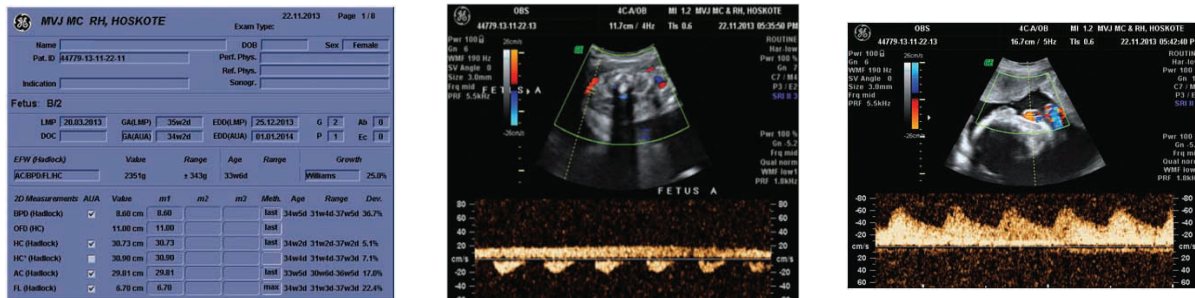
and empty urinary bladder. Umbilical artery doppler demonstrated absent diastolic flow suggestive of moderate placentofetal insufficiency [Table/Fig-5]. Twin B (Recipient twin) demonstrated breech presentation, corresponding to 34 weeks [Table/Fig-6], polyhydramnios (Deepest Vertical Pocket -12cm) [Table/Fig-7], over distended urinary bladder [Table/Fig-8]. Doppler demonstrated normal umbilical artery flow pattern [Table/Fig-9]. Because of the above mentioned findings, diagnosis of Monochorionic diamniotic twin live intrauterine gestations with features of Twin to Twin transfusion syndrome (stage-3) with stuck donor twin was given. With adequate blood transfusion patient was taken up for emergency LSCS. Twin A was delivered first by breech extraction with excess liquor, second twin was extracted with membrane tightly wrapped around the baby. Recipient twin was a female baby weighing 2.01kg with good APGAR score. Donor twin was a
